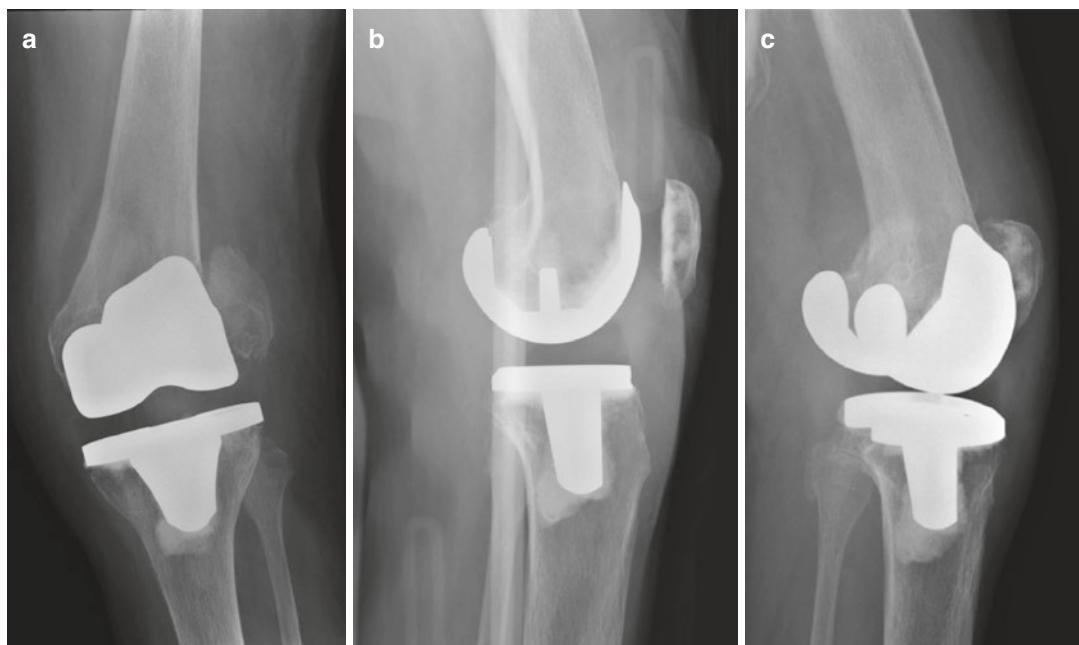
Anteroposterior (AP) (a), lateral (b), and oblique (c) radiographs of failed primary TKA secondary to distal femoral periprosthetic fracture, characterized by
